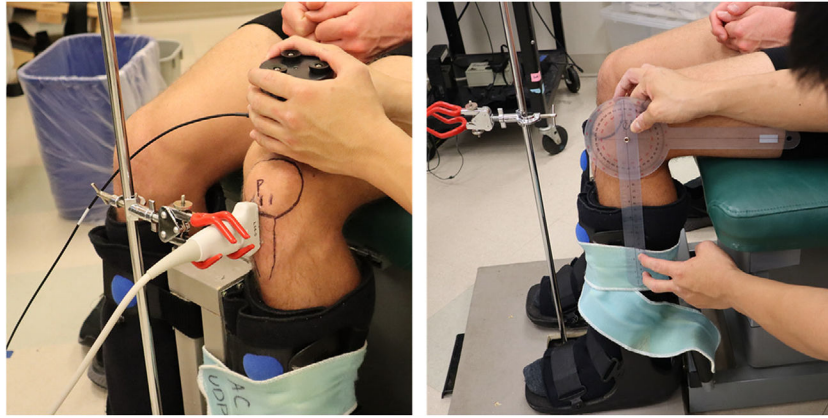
Continuous shear wave elastography (cSWE) setup. Participants were seated with their hips and knees at 90° of flexion with their lower leg stabilized in a custom boot (right). The ultrasound probe was placed on a custom clamp after the region of interest was determined, and the external actuator was placed on the quadriceps tendon above the knee held by the rater (left).
